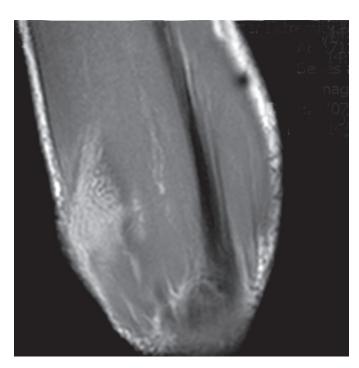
MRI of left forearm showed intramuscular involvement with homogenous high signal intensity area.
